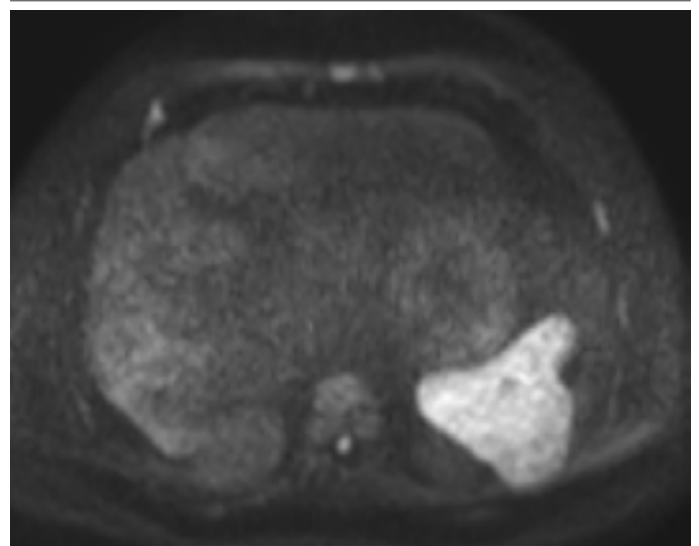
DWI post TARE showing no restricted diffusion. Minimal signal, somewhat wedge shaped, is from T2 signal "shine through" of radiation induced changes
